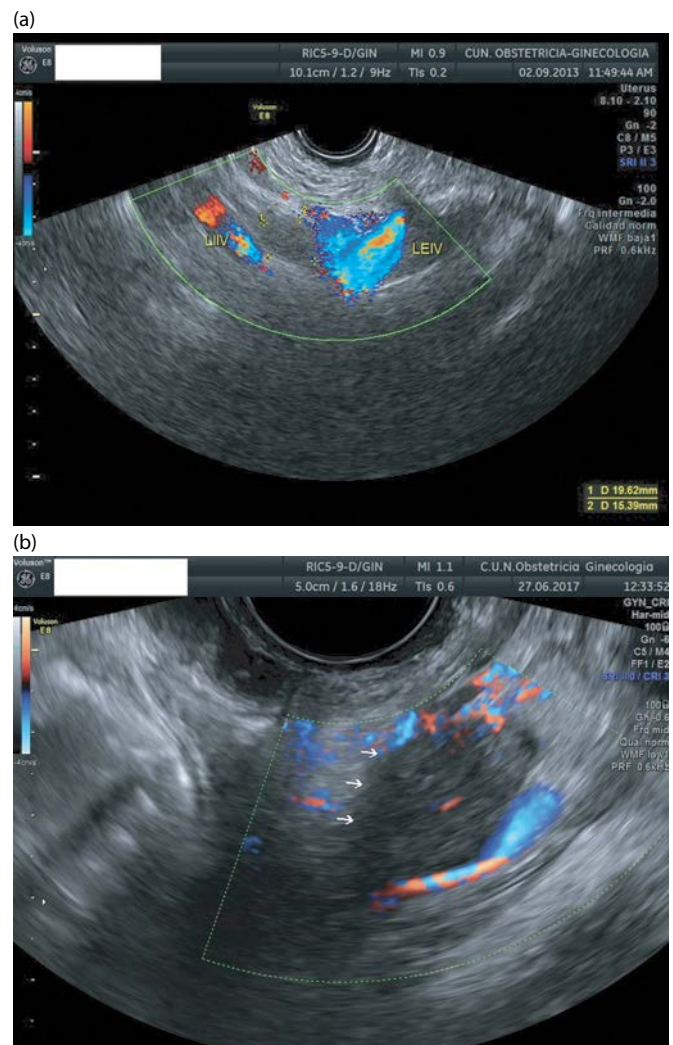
Transvaginal ultrasound showing lymph node assessment in cases of cervical cancer. In (a), the lymph node is located between the left internal iliac vein (LIIV). In case (b), the lymph node is located lying over the left external iliac artery (LEIV).
